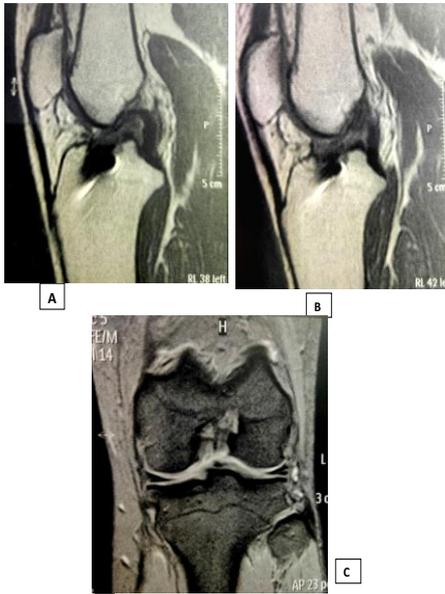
(a) (b) Sagittal PD (c) Coronal GRE MR images in a 28-year-old male show complete tear of ACL graft, with buckling of PCL
